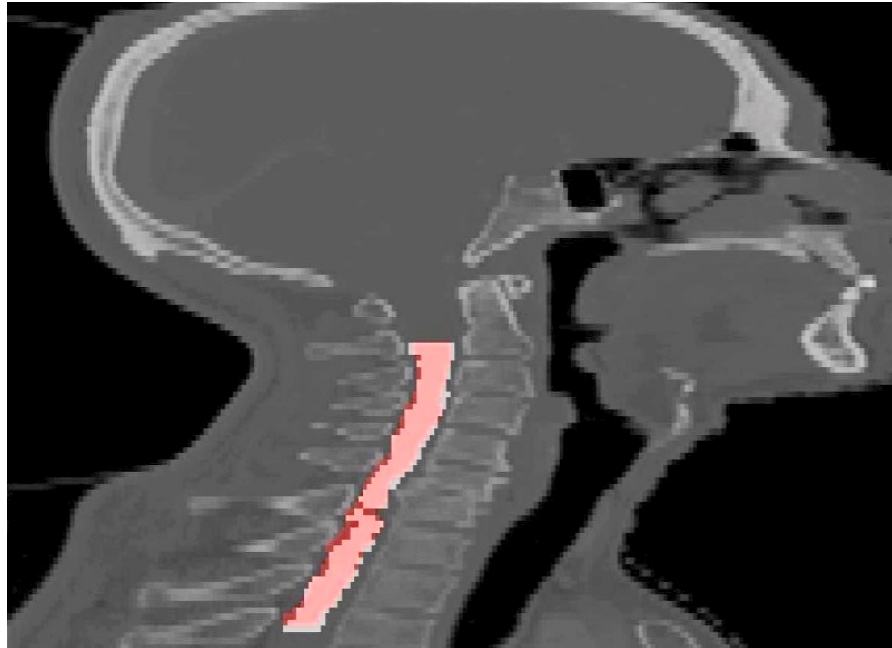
The propagated contour of the spinal cord of a rCT₃ is compared with its original planning contour on planning CT. The pink area represents the propagated contour of the spinal cord. The blue area represents the planning contour of the spinal cord.
